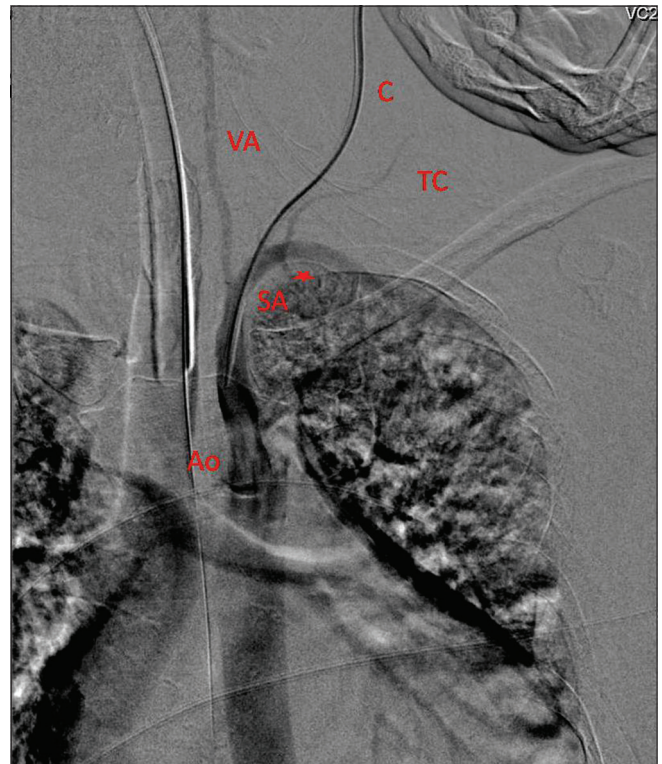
Computed tomography angiography with coronal reconstructed image shows placement of catheter tip in subclavian artery. Ao - Aorta, C- Catheter
